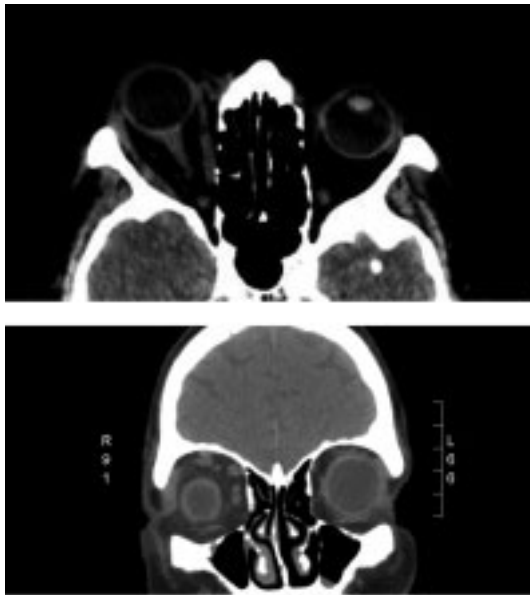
Computed Tomography of the orbit, showing 3 mm proptosis of the right eye after the use of zoledronic acid. Extraocular muscles were not enlarged and not associated with any signs of myositis. The optic nerve and tear gland appeared normal.
